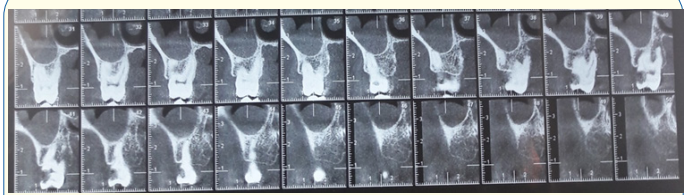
Coronal cuts of CBCT showing mucosal thickening of the left maxillary sinus.
